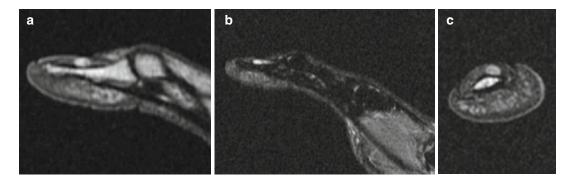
MRI images of a sub-ungual Glomus tumour. (a) T1 weighted post-contrast. (b). sagittal and (c) axial STIR images of the same tumour
